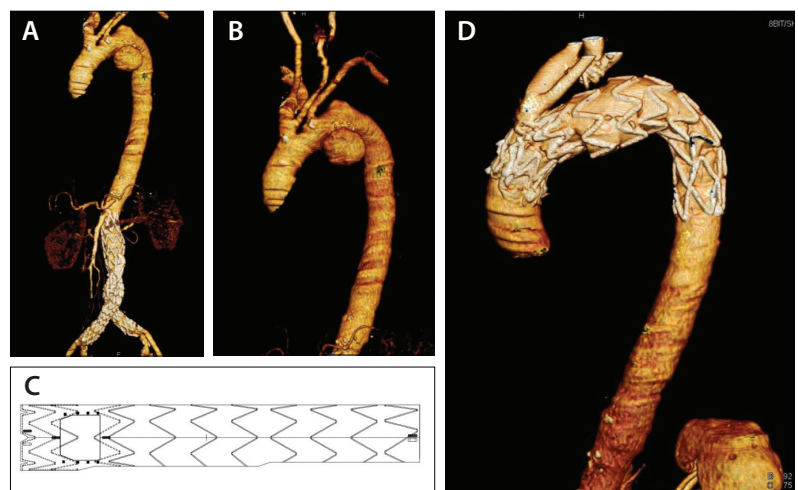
Preoperative CT showing pseudoaneurysm dilatation of the arch with coexisting dilatation (A, B). Case planning with specifications of the custom-made fenestrated RelayNBS Plus device (C). One-year follow-up CT showing complete seal, patent branches, and no endoleaks (D).
